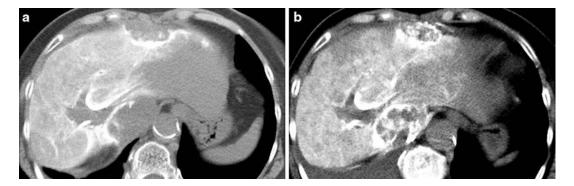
Management of drug distribution by the embolization of parasitic artery with NBCA–lipiodol mixture. (a) CTA via the indwelling catheter/port system shows the intrahepatic areas without contrast enhancement. (b) CTA via the indwelling catheter/port system after the embolization of the right inferior phrenic artery and the left internal mammary artery shows the significant better
